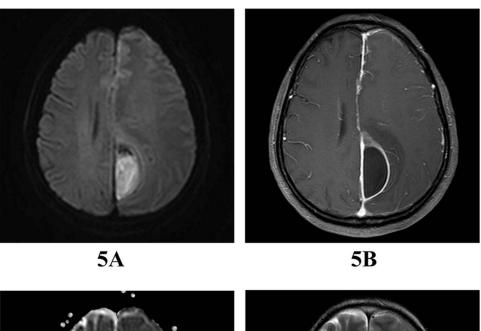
Cranial MR enhancement on July 28: There was meningeal thickening and abnormal enhancement, along with empyema adjacent to the cerebral falx and tentorium cerebelli. (A) T2 sequence showing a high signal bar on the left side of the cerebral falx, locally wrapped and considered to be empyema. (B) FLAIR sequence showing a low signal bar on the left side of the cerebral falx, locally wrapped.
